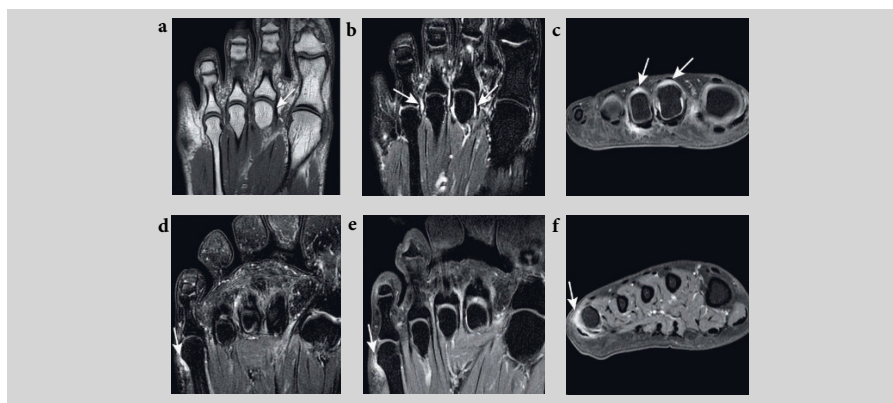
Magnetic resonance images (MRIs) of the left foot in a patient who is positive for anti-citrullinated peptide antibodies with arthralgia but without clinically-detectable arthritis. Axial T1 TSE (a), T2 TSE fat saturation (b, d), and axial and coronal T1 TSE fatsat with gadolinium (c, e, f) of the forefoot on 1.5T extremity MRI. Intact cortical bone of the metatarsal phalangeal (MTP) joints on T1 TSE image (a). The high signal intensity on T2 TSE in the MTP joints (b), enhances after gadolinium (c) and is consistent with synovitis. This is well visualized on the coronal T1 TSE fatsat images with gadolinium at the level of the MTP 2 and 3 (c; arrows). The MTP 5 joint shows high signal intensity on (d) axial T2, and enhancement on (e) axial and (f) coronal T1 TSE fatsat (arrows), also consistent with synovitis.
